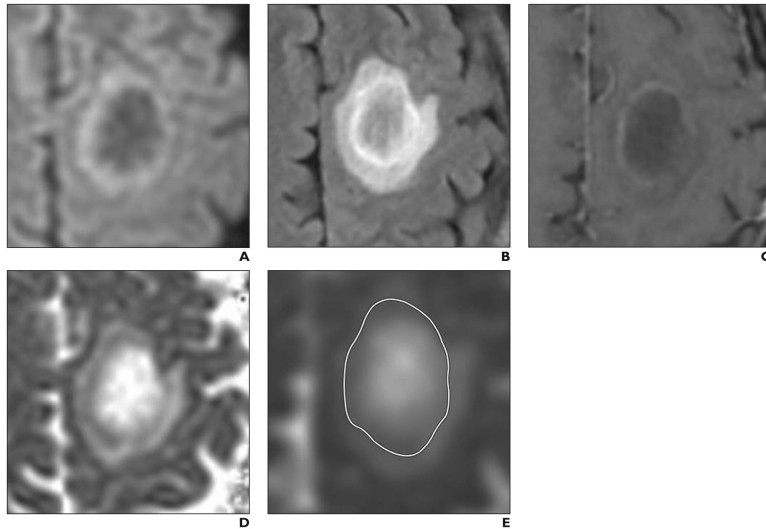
MRI of 36-year-old man with tumefactive demyelinating lesion (TDL). A–E, Axial DW image (A), axial T2-weighted FLAIR image (B), axial gadolinium-enhanced T1-weighted image (C), axial apparent diffusion coefficient (ADC) map (D), and axial ADC map (E) with ROI (*outline*, E) drawn on it after review of all images. ROI was drawn to include whole lesion and includes rim of reduced diffusion seen on DW image (A) and ADC maps (D and E) and corresponding to incomplete rim of contrast enhancement seen on gadolinium enhanced T1-weighted image (C). Minimum ADC (ADC_{min}) measured 0.764, and average ADC (ADC_{avg}) measured 1.620. Relatively younger age of patient and high ADC_{min} , high ADC_{avg} , and incomplete rim of contrast enhancement all suggest TDL. Diagnosis of TDL was proven at biopsy.
